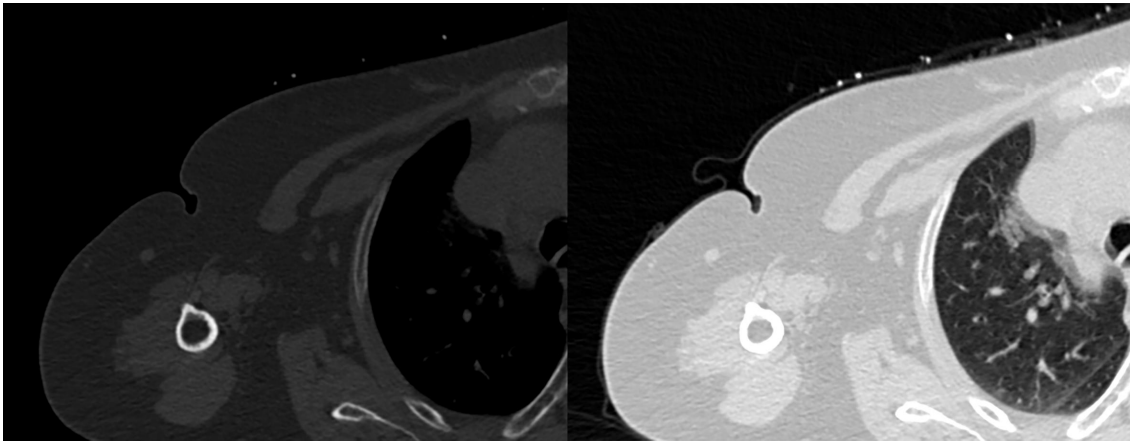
contrast stretching applied to a CT scan image revealing the details in the data.
